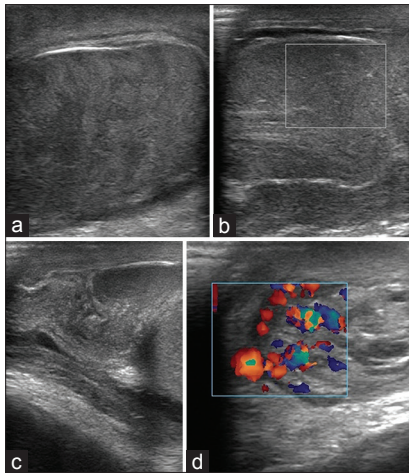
(a) Testis enlarged and appears heterogeneously hypoechoic. (b) Complete absence of detectable flow in the symptomatic testis. (c) Intrascrotal portion of the cord appears as edematous, round, ovoid, or curled echogenic extra testicular mass; with the epididymal head wrapped around it. (d) Whirlpool sign - color Doppler (CD) shows spiral twisting of vessels (arrow) proximal to the torsion knot
